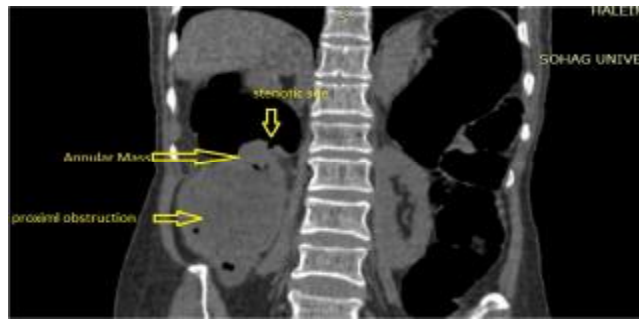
Incomplete colonoscopy because of ascending colon cauliflower mass with shouldering causing distension of the proximal part of the ascending colon by fecal matter. As we resort to inflate the colon using air in CT colonography, so detection of diverticulae was easier by CT colonography than colonoscopy. We could detect up to 60 diverticulae in 5 patients with sensitivity of about 99%. The largest diverticula detected measured 15mm and the smallest one measured 2.5mm.
